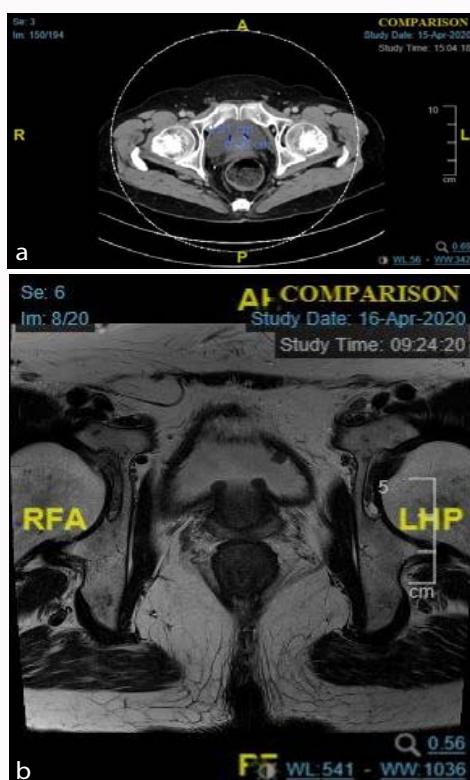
(Left to Right) a) CT AP showing nodular foci in bladder b) MRI pelvis with imaging of bladder.
